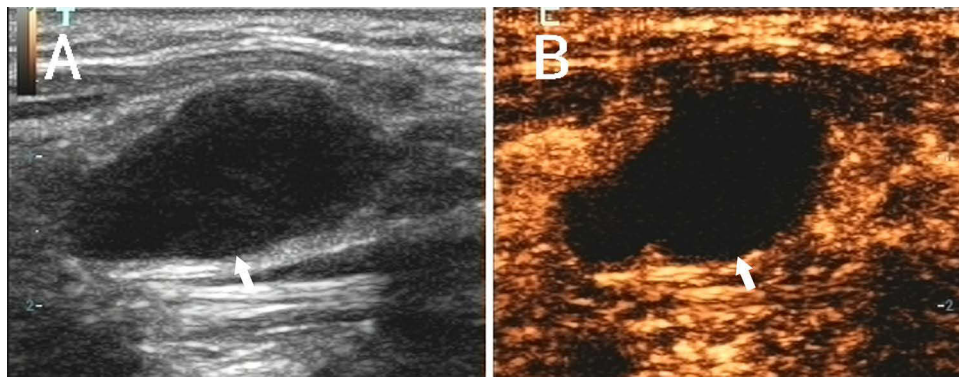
The ultrasound image of a non-responder cervical tuberculous lymphadenitis patient (45-year-old man). (A) Conventional ultrasound showed lymph node (indicated by arrows), the maximum length diameter was 2.4 cm, and short diameter was 1.2 cm. (B) Contrast-enhanced ultrasound showed that the area without enhancement was lymph node necrosis (arrows), the necrotic rate $\geq 50\%$.
